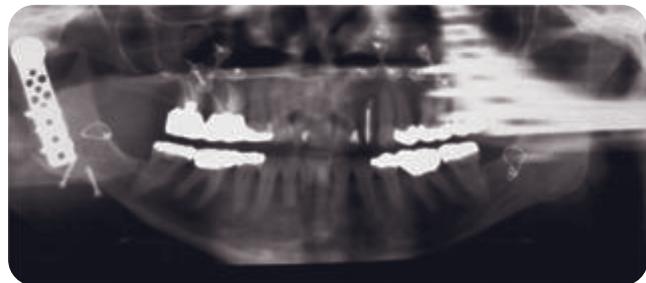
Posttreatment panoramic radiograph. The patient was followed for several years posttreatment. Periodic occlusal refinement was necessary as expected. Most likely, remodeling of the fossa occurred in response to the titanium condyle.
